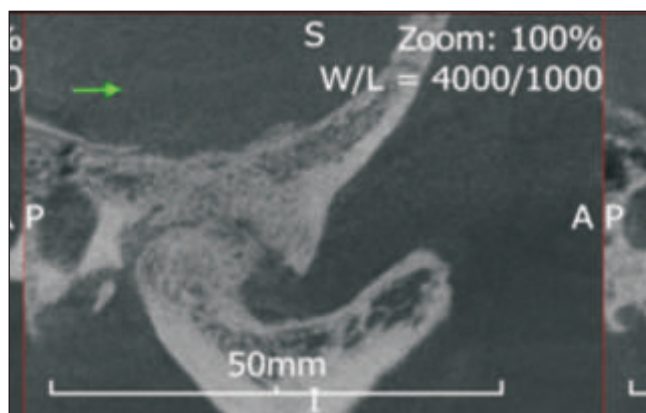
3D CBCT AND SAGGITAL VIEW of TMJ (Preoperative)
